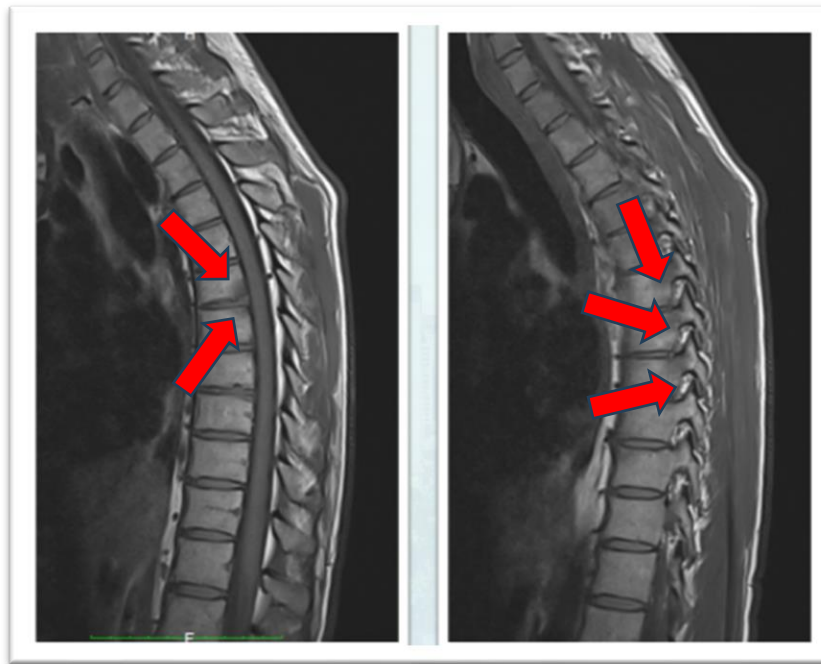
Sagittal MRI T1: hypointense signal areas at the level of the opposed posterior edges involving several middle-dorsal vertebrae (arrows).*
